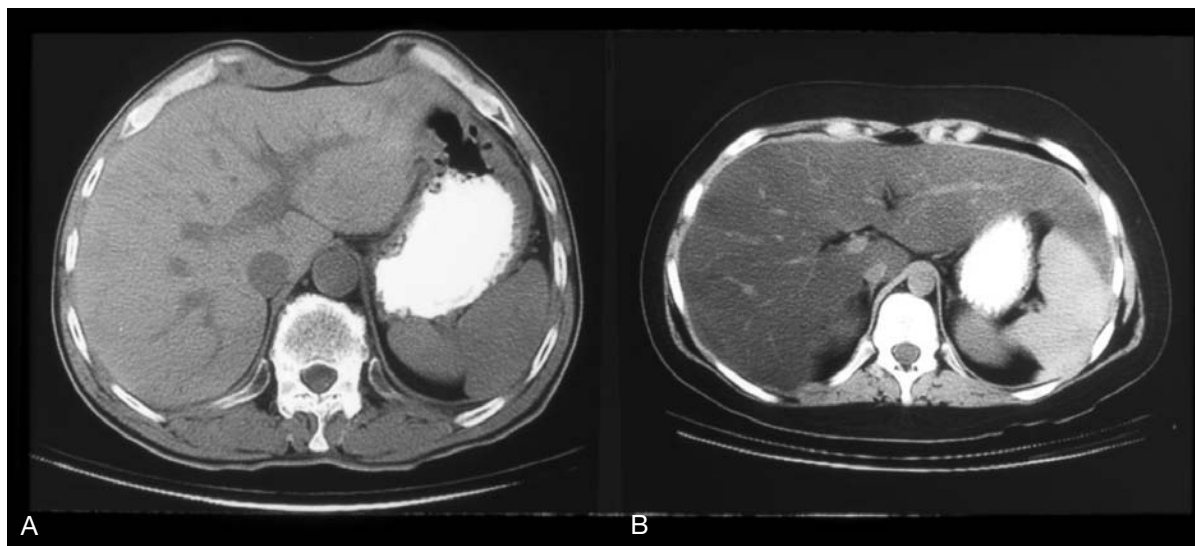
Features of hepatic steatosis visualized with computed tomography. *A*, Normal liver has no attenuation of the signal compared with the spleen, whereas, *B*, liver with fatty infiltration has an attenuated signal compared with the spleen.
